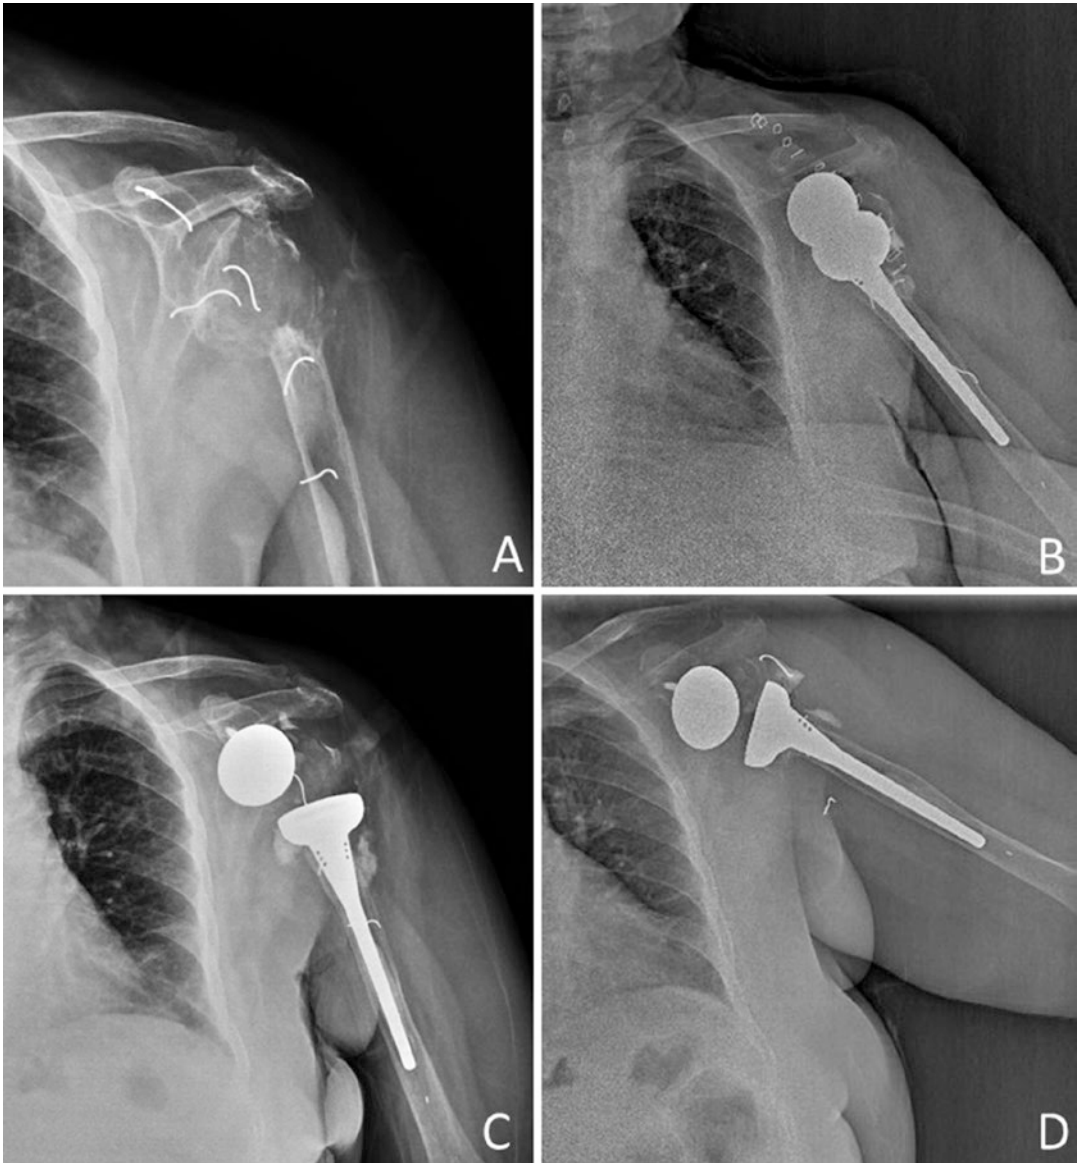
Radiographs of a patient with a history of repeated right shoulder surgery; (a) anterior-posterior radiograph before RTSA, (b) postoperative anterior-posterior radiograph, (c) postoperative first-month
